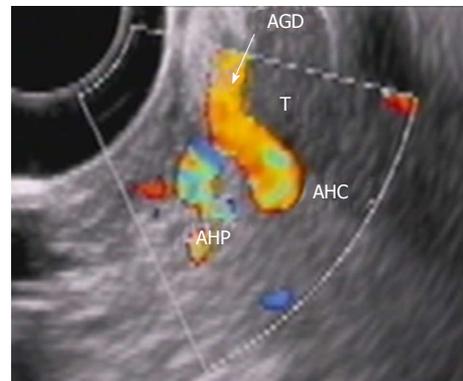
Endoscopic ultrasound. Tumor (T) abutment to gastroduodenal artery (AGD and arrow) without its encasement. HAC: Common hepatic, HAP: Proper hepatic artery.
